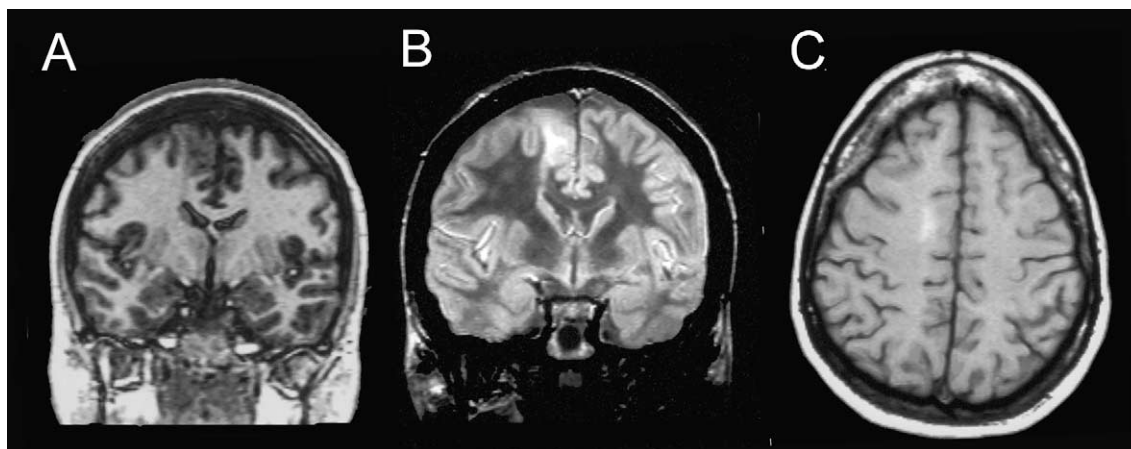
MRI of a 33-year-old woman with bilateral asymmetric tonic seizures since the age of 11 years. The MRI shows a mass in the right superior frontal gyrus. Signal characteristics are: mildly hyperintense on T1 (A and C), hyperintense on spin-density (B).
